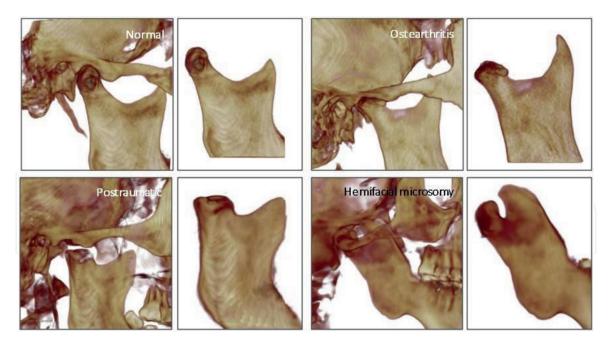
Cone bean CT of the right adult TMJ in normal conditions, osteoarthritis, posttraumatic, and hemifacial microsomy. Images obtained from Instituto Asturiano de Odontolgía, Oviedo, Spain.
